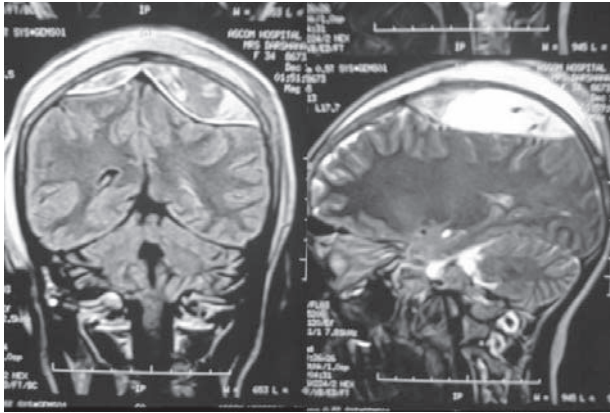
MRI brain Coronal & Sagittal views showing the bilateral vertex EDH with mass effect
